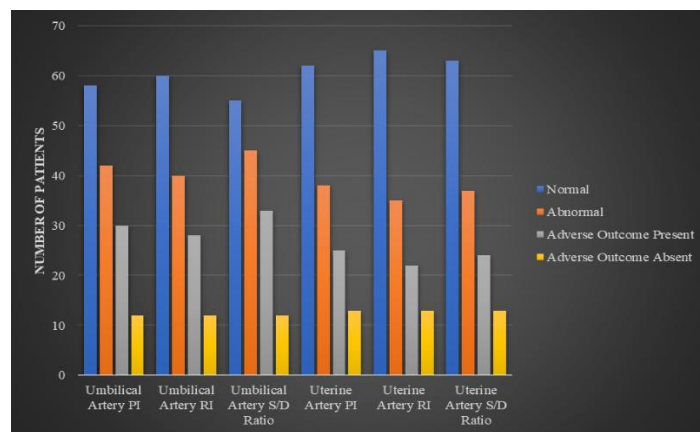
Umbilical and Uterine Artery Doppler Findings in IUGR
